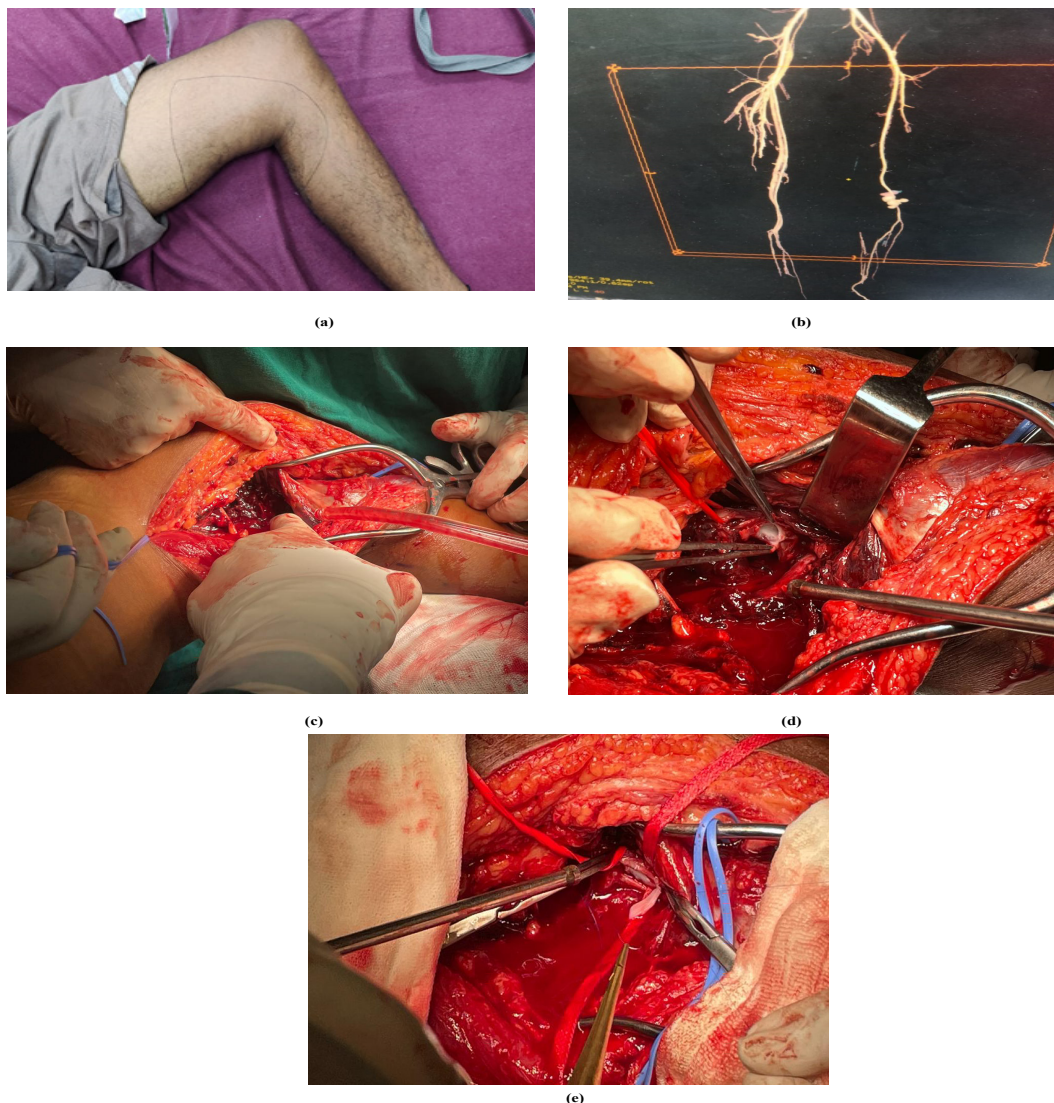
(a) Tense swelling with bruit and flexion deformity. (b) CT angiogram: 7.6*4.2*3.4 cm left mid popliteal artery pseudo aneurysm. (c) Mid Popliteal artery pseudo aneurysm with thrombus. (d) Mid Popliteal artery rent. (e) Rent closed with vein patch.
